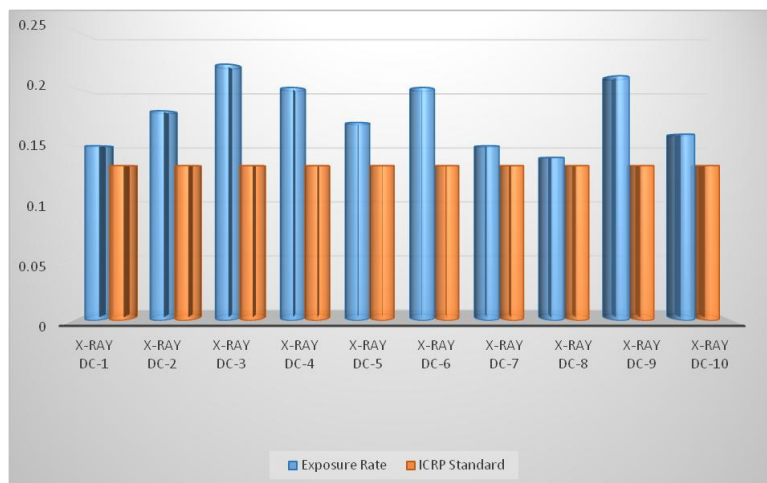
Exposure rate of the sampled X-ray diagnostic centers with ICRP, 2003
